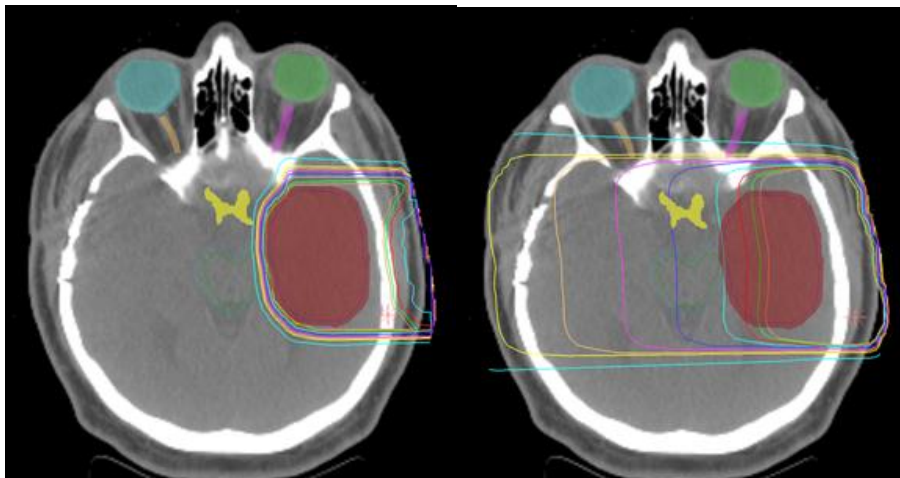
Dose map from a target in the left hemisphere of the brain (shown in red) treated with a single proton beam (left) and a single x-ray beam (right). Observe the dose conformality and sharp dose fall-off of the proton plan (3).
